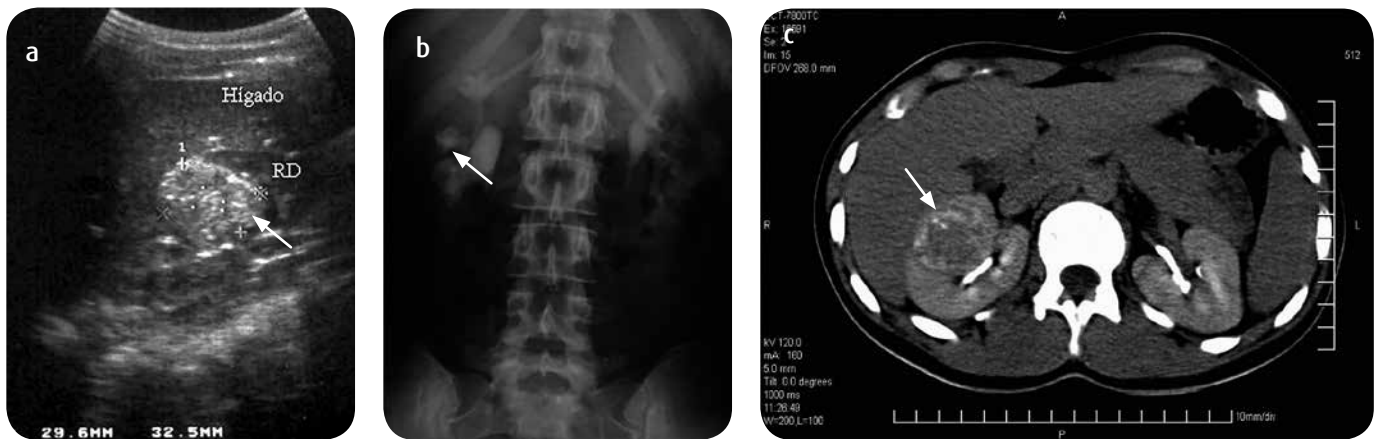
Right RCC in a 16-year-old patient. Stage III. a) Ultrasound: heterogeneous mass in the upper pole-interpolar region. b) Excretory urography: inferior displacement of the middle calyceal group and slight dilatation of the excretory system. c) Renal-CT: study after the application of the contrast medium: mass with heterogeneous enhancement towards the anterior aspect of the superior pole-interpolar region of the right kidney.
